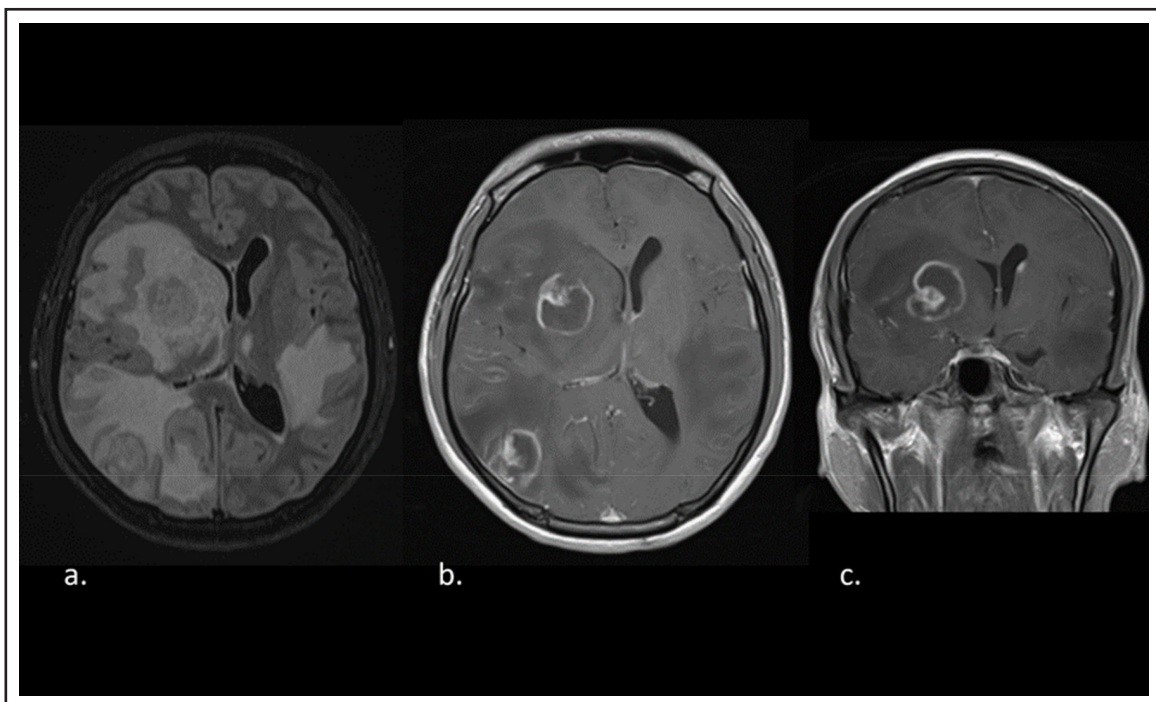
MRI on second day of admission. a) Axial T2 Flair image showing multiple rounded lesions with extensive perilesional oedema and mass effect to surrounding structures. b) Axial and c) Coronal T1 post contrast images showing multiple ring enhancing lesions with eccentric enhancing nodules giving the appearance of eccentric target sign.
